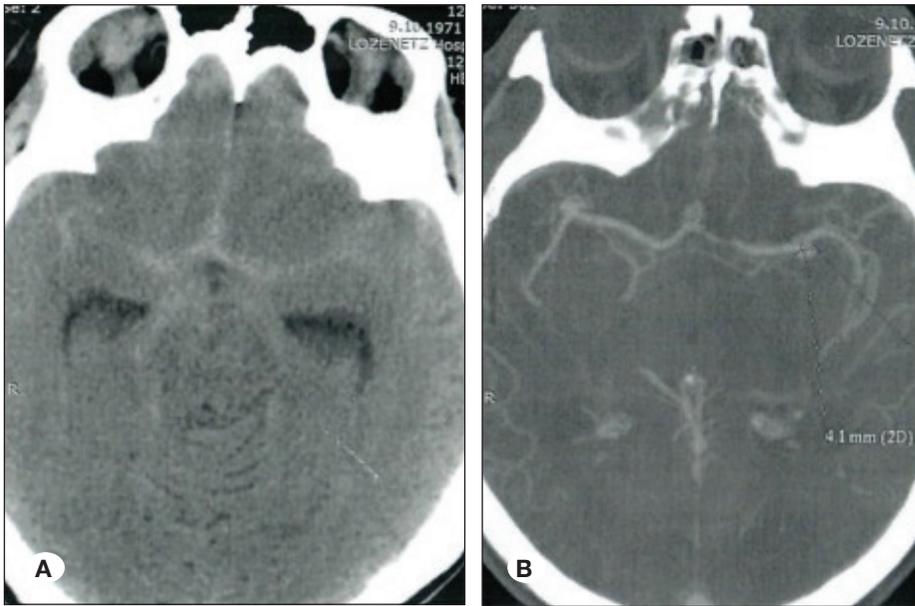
A) Case 3. A massive SAH covering both Sylvian fissures and interhemispheric fissure; 1. B) 3D-CT angiography with data for 3 intracranial aneurysms in the right and left middle cerebral arteries and an aneurysm of the anterior communicating artery.
